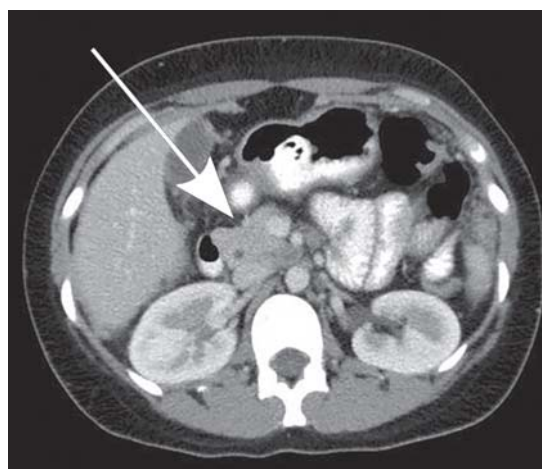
Extrapulmonary manifestation of TB with abscess formation around the abdominal aorta (arrow) (abdominal computed tomography, axial section)
